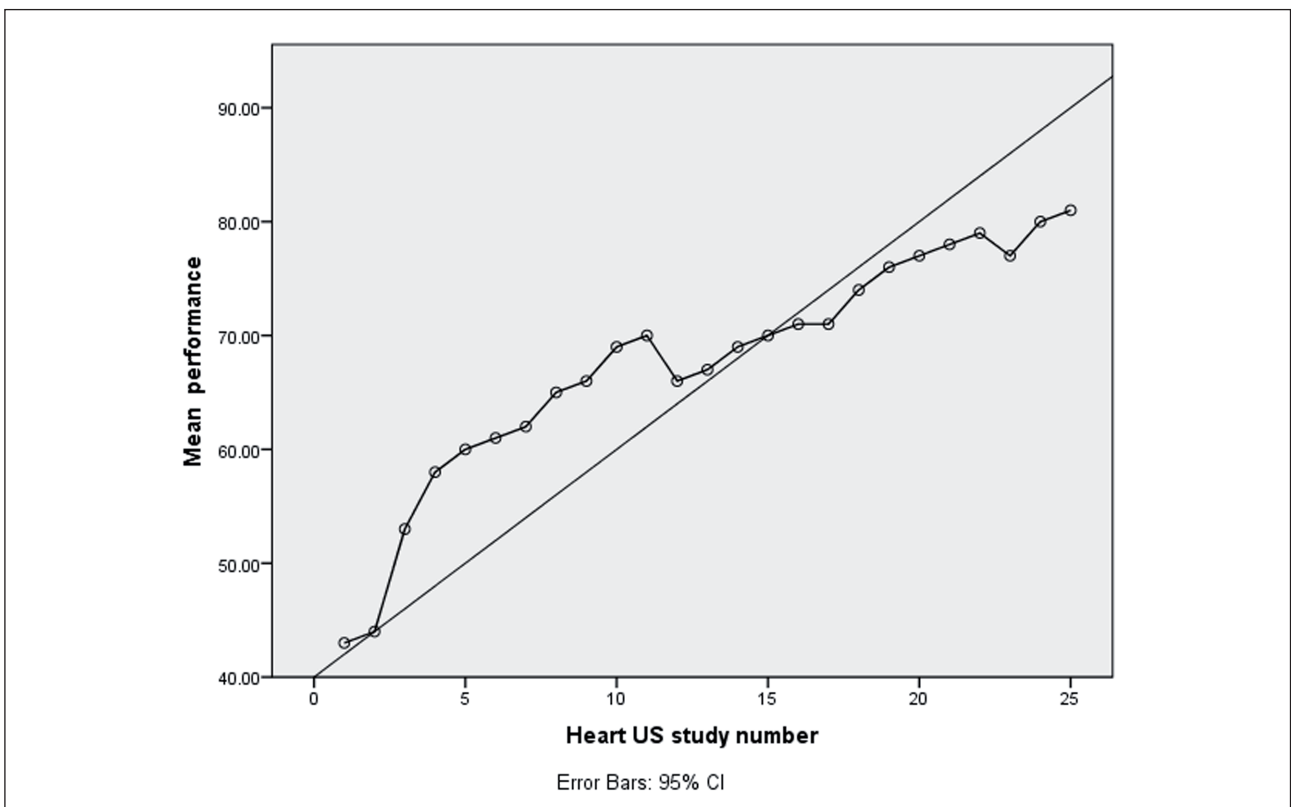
Correlation curve of fellows’ performance in focused heart ultrasound (FHUS), horizontal axis represents order number of studies, and vertical axis represents mean of performance mark.
